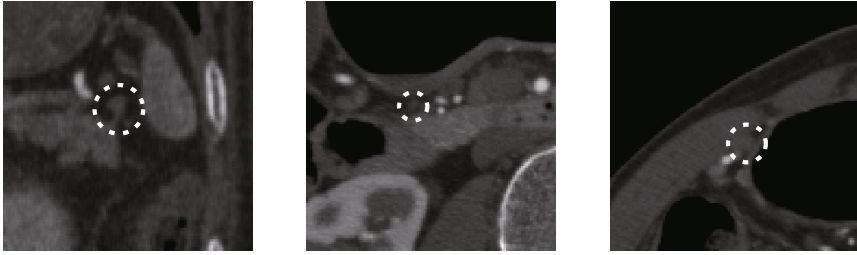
Examples of lymph nodes in CT images. The lymph nodes are indicated by circles.
